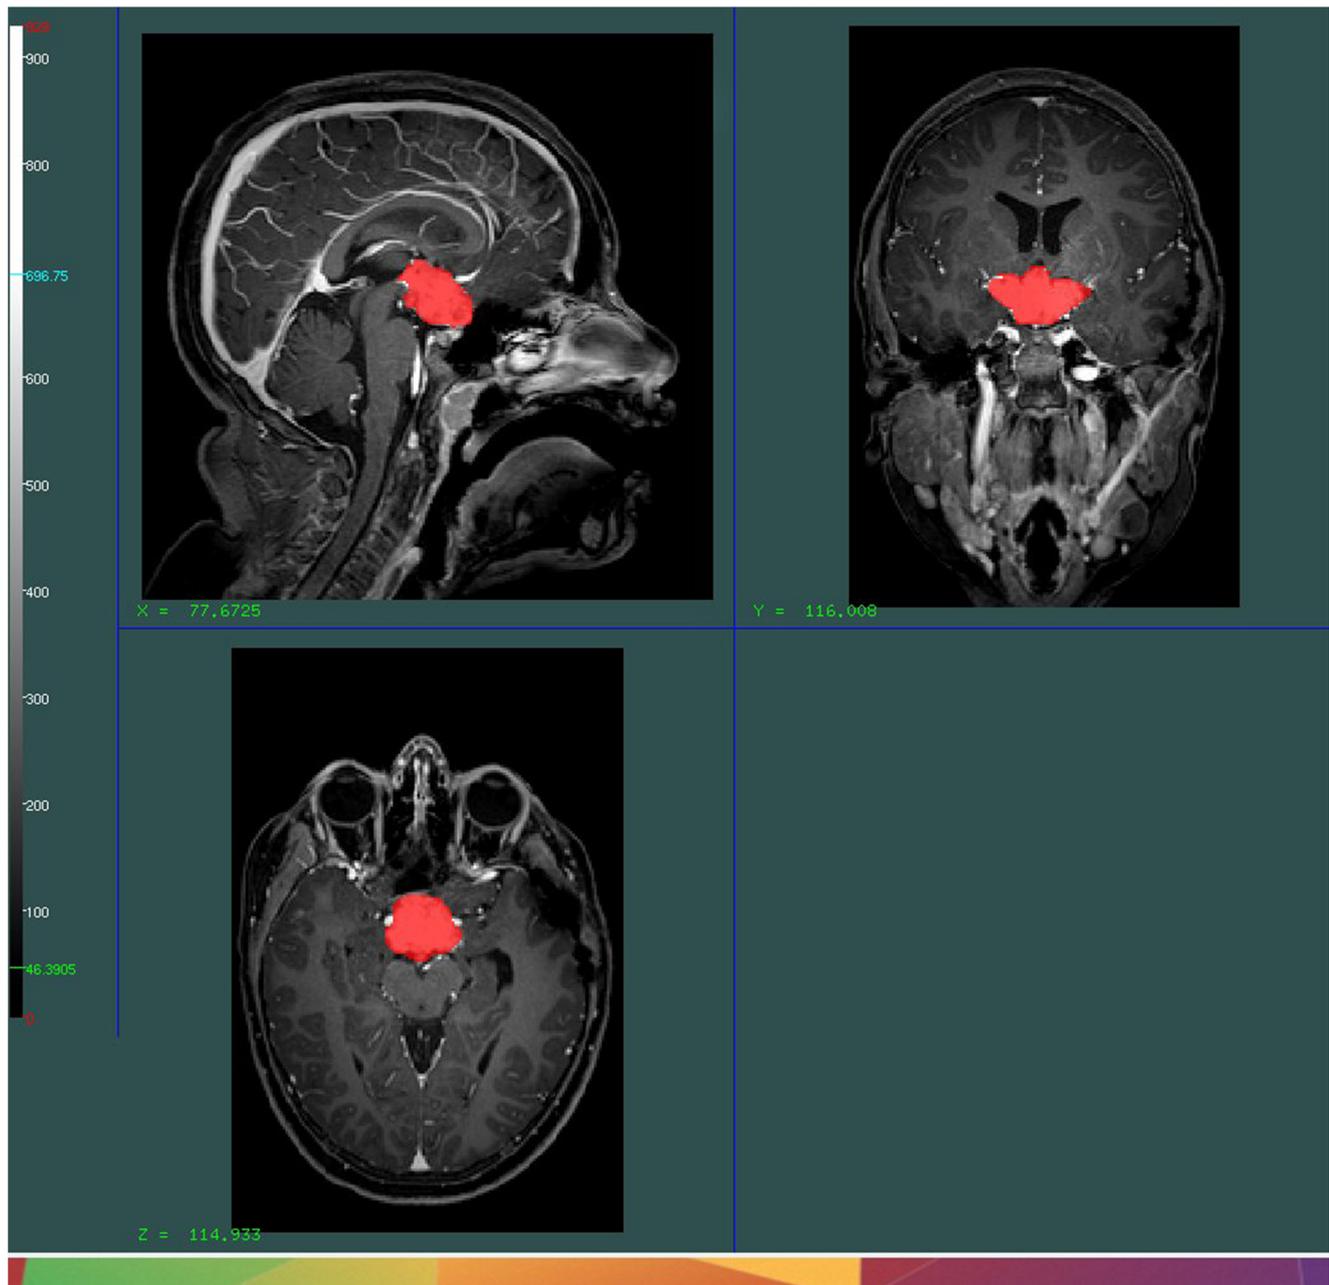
Example of volumetric assessment of a chiasmatic-hypothalamic lesion, using MRI (T1-weighted images after gadolinium) and display software
